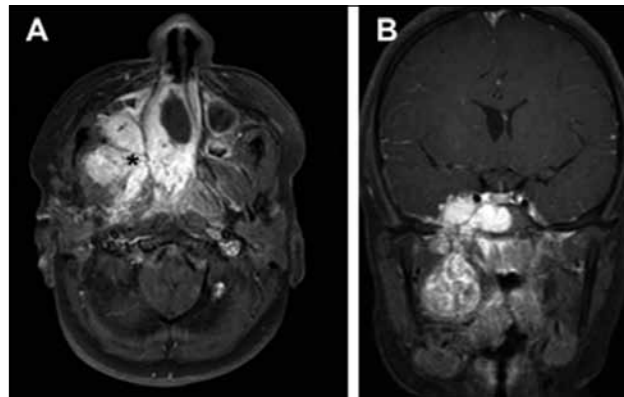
A) Axial MRI and B) Coronal MRI demonstrating an extensive right angiofibroma with extension into the middle cranial fossa, involvement of the right internal carotid artery and deep extension into the parapharyngeal space with airway compromise. This was fully excised with staged surgical procedures.
